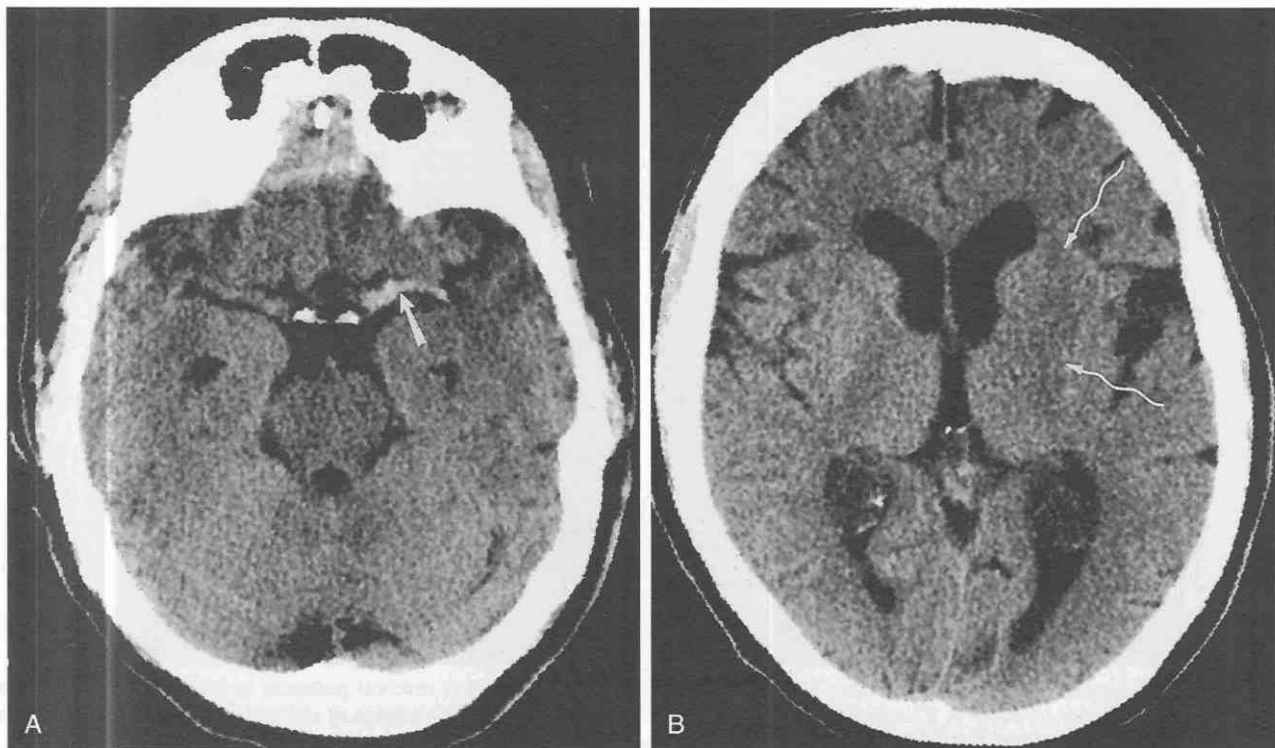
Obscuration of the lentiform nucleus. *A*, Unenhanced axial CT scan shows hyperdensity within the proximal (M1) segment of the middle cerebral artery (arrow). *B*, There is decreased density with loss of definition within the left basal ganglia (wavy arrow). Obscuration of the lentiform nucleus and hyperdense middle cerebral artery is one of the earliest signs of stroke on an unenhanced CT scan.
